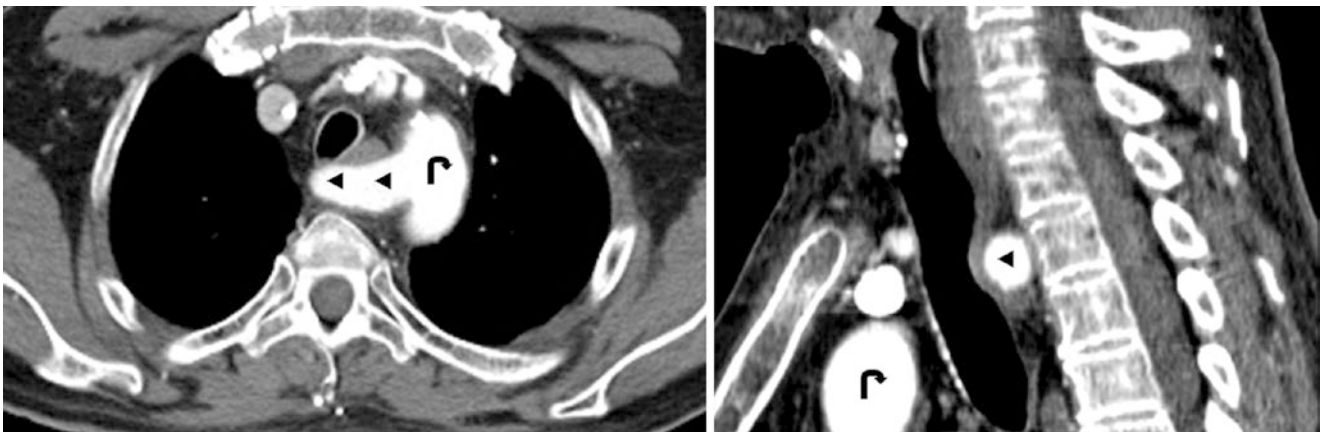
51-year-old with a left-sided aortic arch (curved arrow) and a retroesophageal RSCA (left-facing arrowheads) noted on axial (*left*) and sagittal (*right*) reformats from a contrast-enhanced CT scan of the upper chest and lower neck. *Aortic Arch* (curved arrows); *IA*
